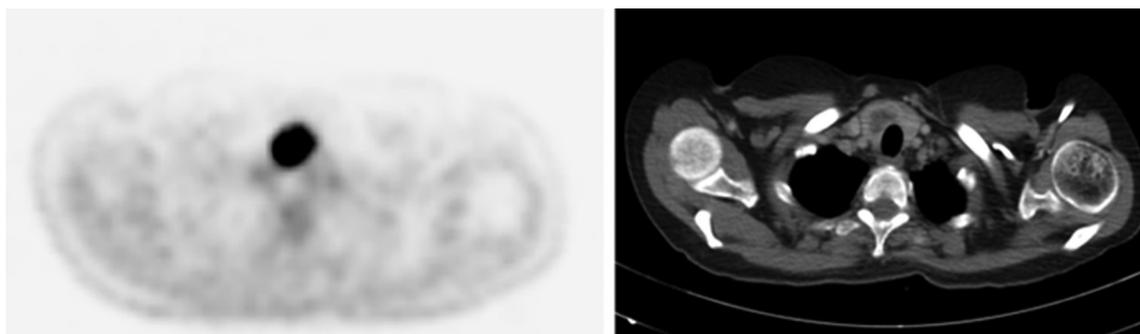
A 59-year-old female patient with a diagnosis of gastric carcinoma was referred for staging ^{18}F -FDG PET/CT scan. Imaging was performed 60 minutes after a dose of 294 MBq, on an integrated 16-slice PET/CT scanner, with scanning from the vertex to the mid-thigh. ^{18}F -FDG PET/CT scan axial views of the lower neck showed a hypermetabolic, heterogeneously enhancing right thyroid nodule with low attenuation [2.7 cm, standardized uptake value (SUV) 17.5]. The left thyroid lobe was unremarkable both radiologically and metabolically.
